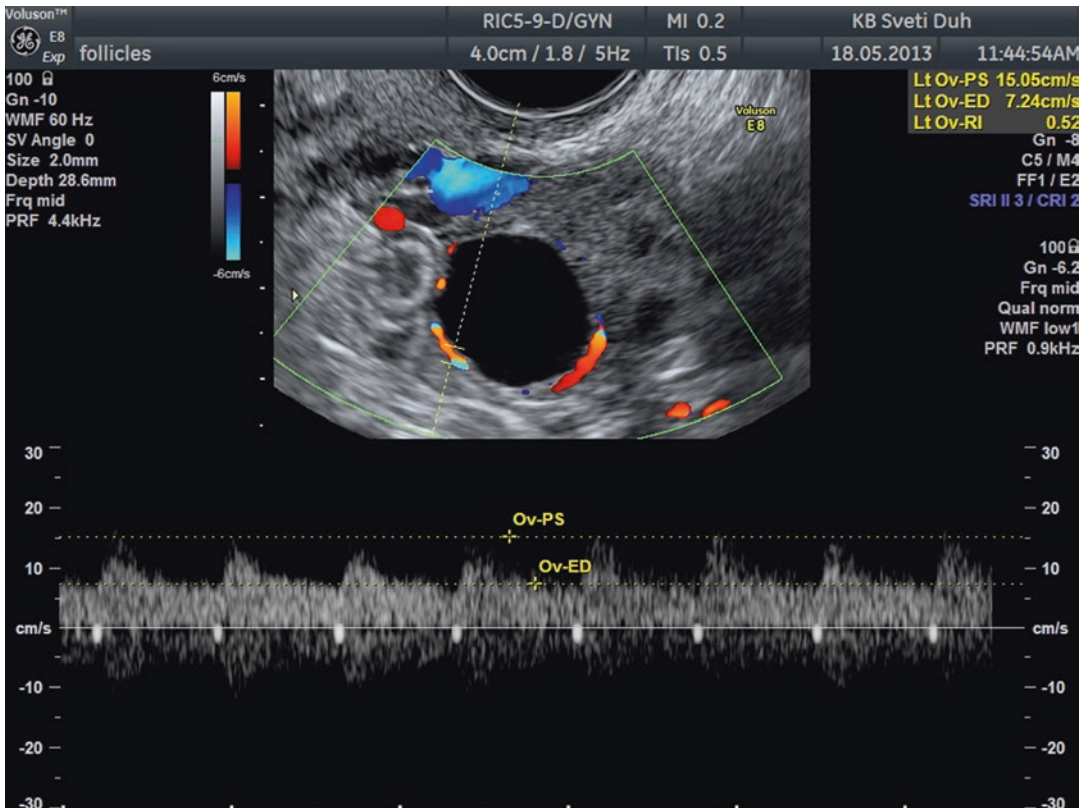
Transvaginal color Doppler image of perifollicular vascularization of preovulatory follicle
